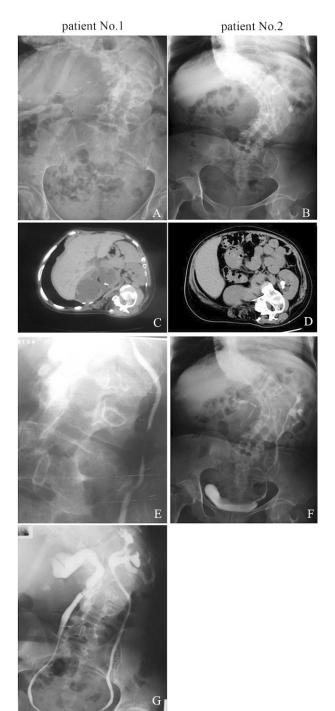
Preoperative radiologic assessment of 2 scoliotic patients with urolithiasis: KUB radiograph (A and B) revealed the scoliotic curvature of the spinal column and the presence of urinary calculi; upper abdominal CT scan (C and D) showed the anatomy of the diseased kidney in relation to the surrounding organs; and intravenous urography (E and F) and retrograde urography (G) characterized the excretory function of the diseased kidney and the location of urinary obstruction.
